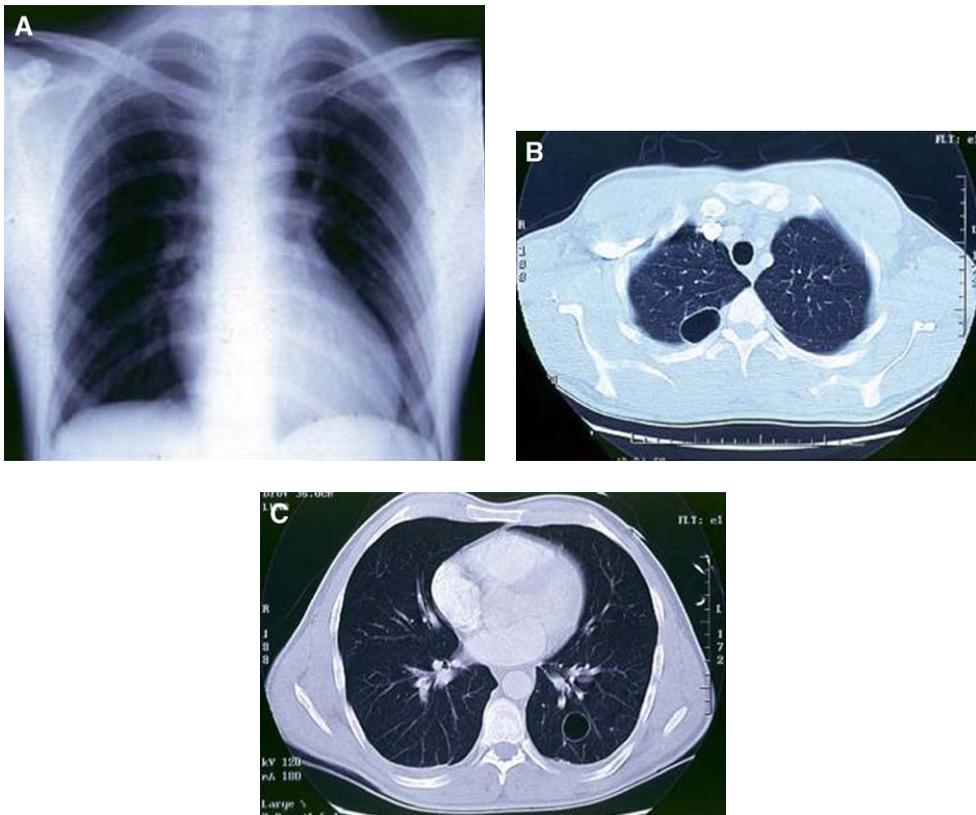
(A) Chest radiograph of a 38-year-old sport scuba diver who complained of sudden leg paralysis and right-sided chest tightness after an uneventful 25-m dive with 20 minutes of bottom time in the Red Sea. The radiograph was taken after the initial treatment for decompression illness and repatriation. Chest CT scan of the same diver shows bilateral lung bullae in the right upper lobe (B) and in the left lower lobe (C). (Courtesy of Armin Kemmer, MD, Murnau, Germany.)
